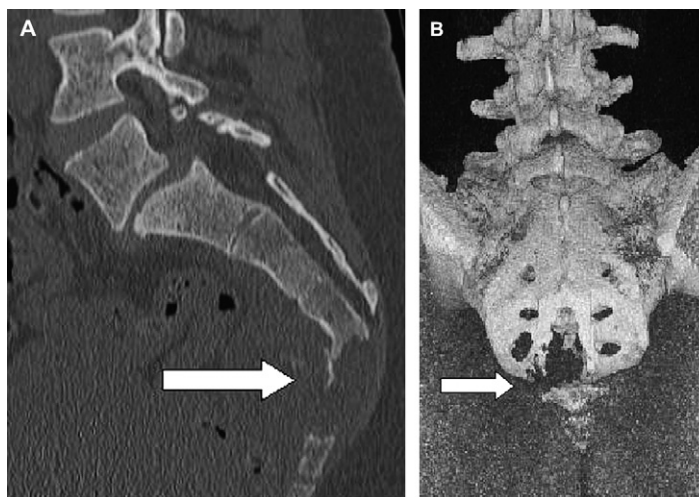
CT of sacral chordoma shows lytic destruction on two-dimensional sagittal reconstruction (A) and three-dimensional reconstruction (B) (arrows).
